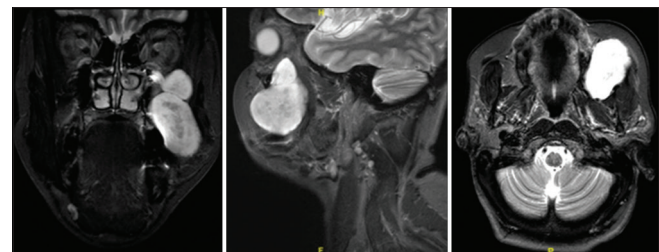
MRI of patient 2, showing a well-delineated lobulated spindle-shaped lesion epicentred along the course of the left infraorbital nerve, which extends from the pterygopalatine fossa
